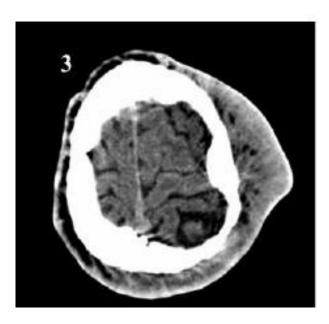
CT – Brain: shows diffuse extra cranial soft tissue density mass with minimal calvarial thickening.
